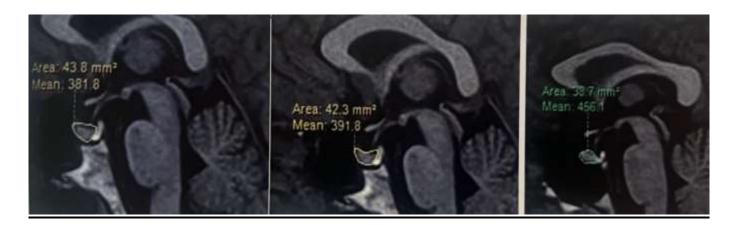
A 32 year old male with history of martial discord, underwent MRI within 3 weeks of onset of severe Depression.
